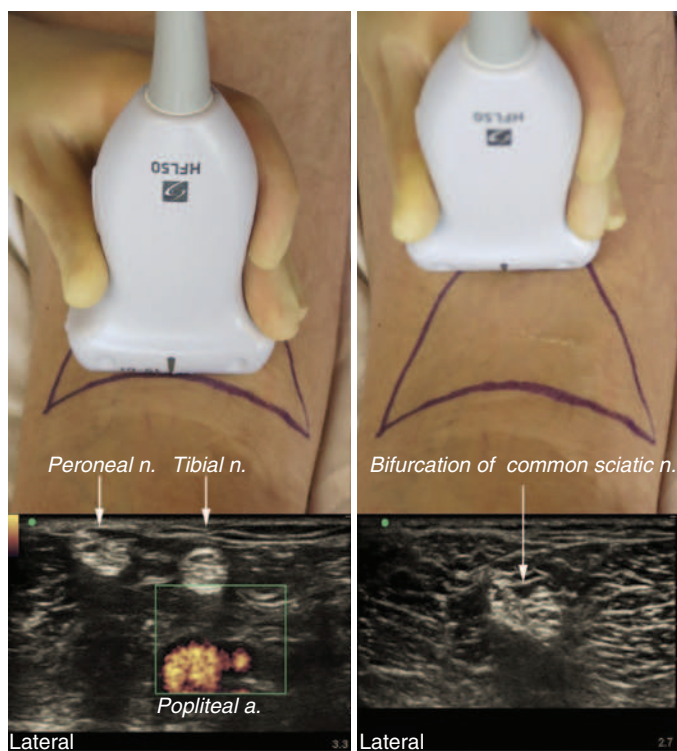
Ultrasound visualization of the distal sciatic nerve bifurcation at the popliteal fossa. The sciatic nerve travels down the posterior leg, then bifurcates into the peroneal and tibial branches in the popliteal fossa. This distinctive bifurcation is a useful ultrasonographic landmark. After bifurcation, the tibial nerve courses medially and the common peroneal nerve laterally.
